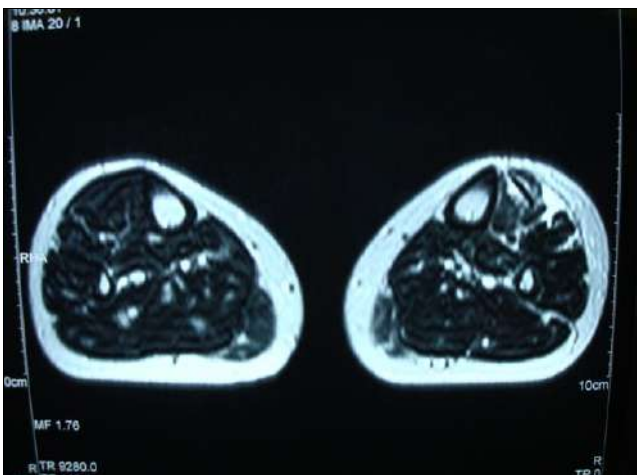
MRI axial view showing peri-musculotendinous effusion around the distal part of the tibialis anterior area
